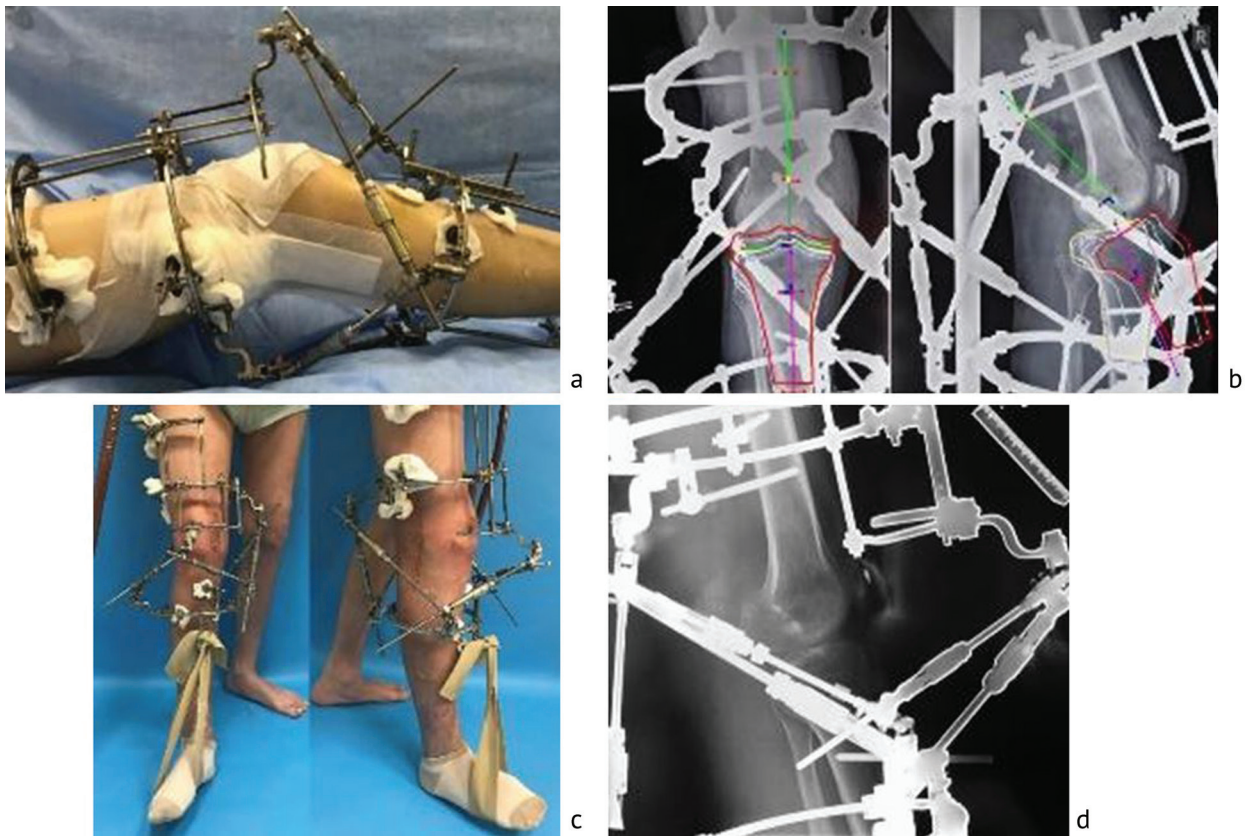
Application of the orthopedic hexapod: (a) appearance after placement of the orthopedic hexapod; (b) calculation of lower leg extension in a computer program; (c, d) a photograph and a radiograph in lateral projection after completion of the lower leg extension stage
